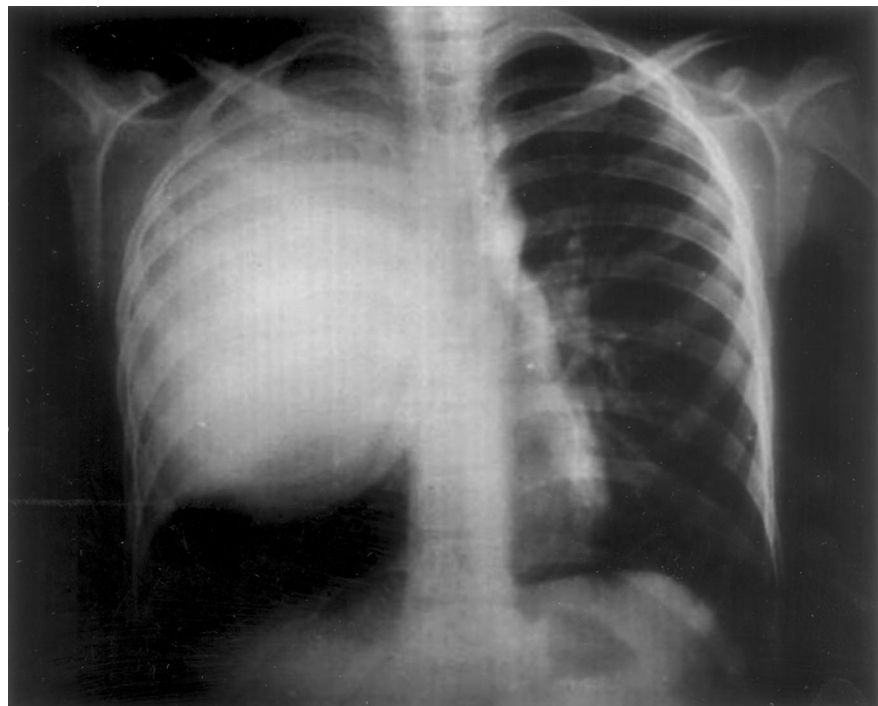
Chest radiograph showing a giant lung hydatid cyst
